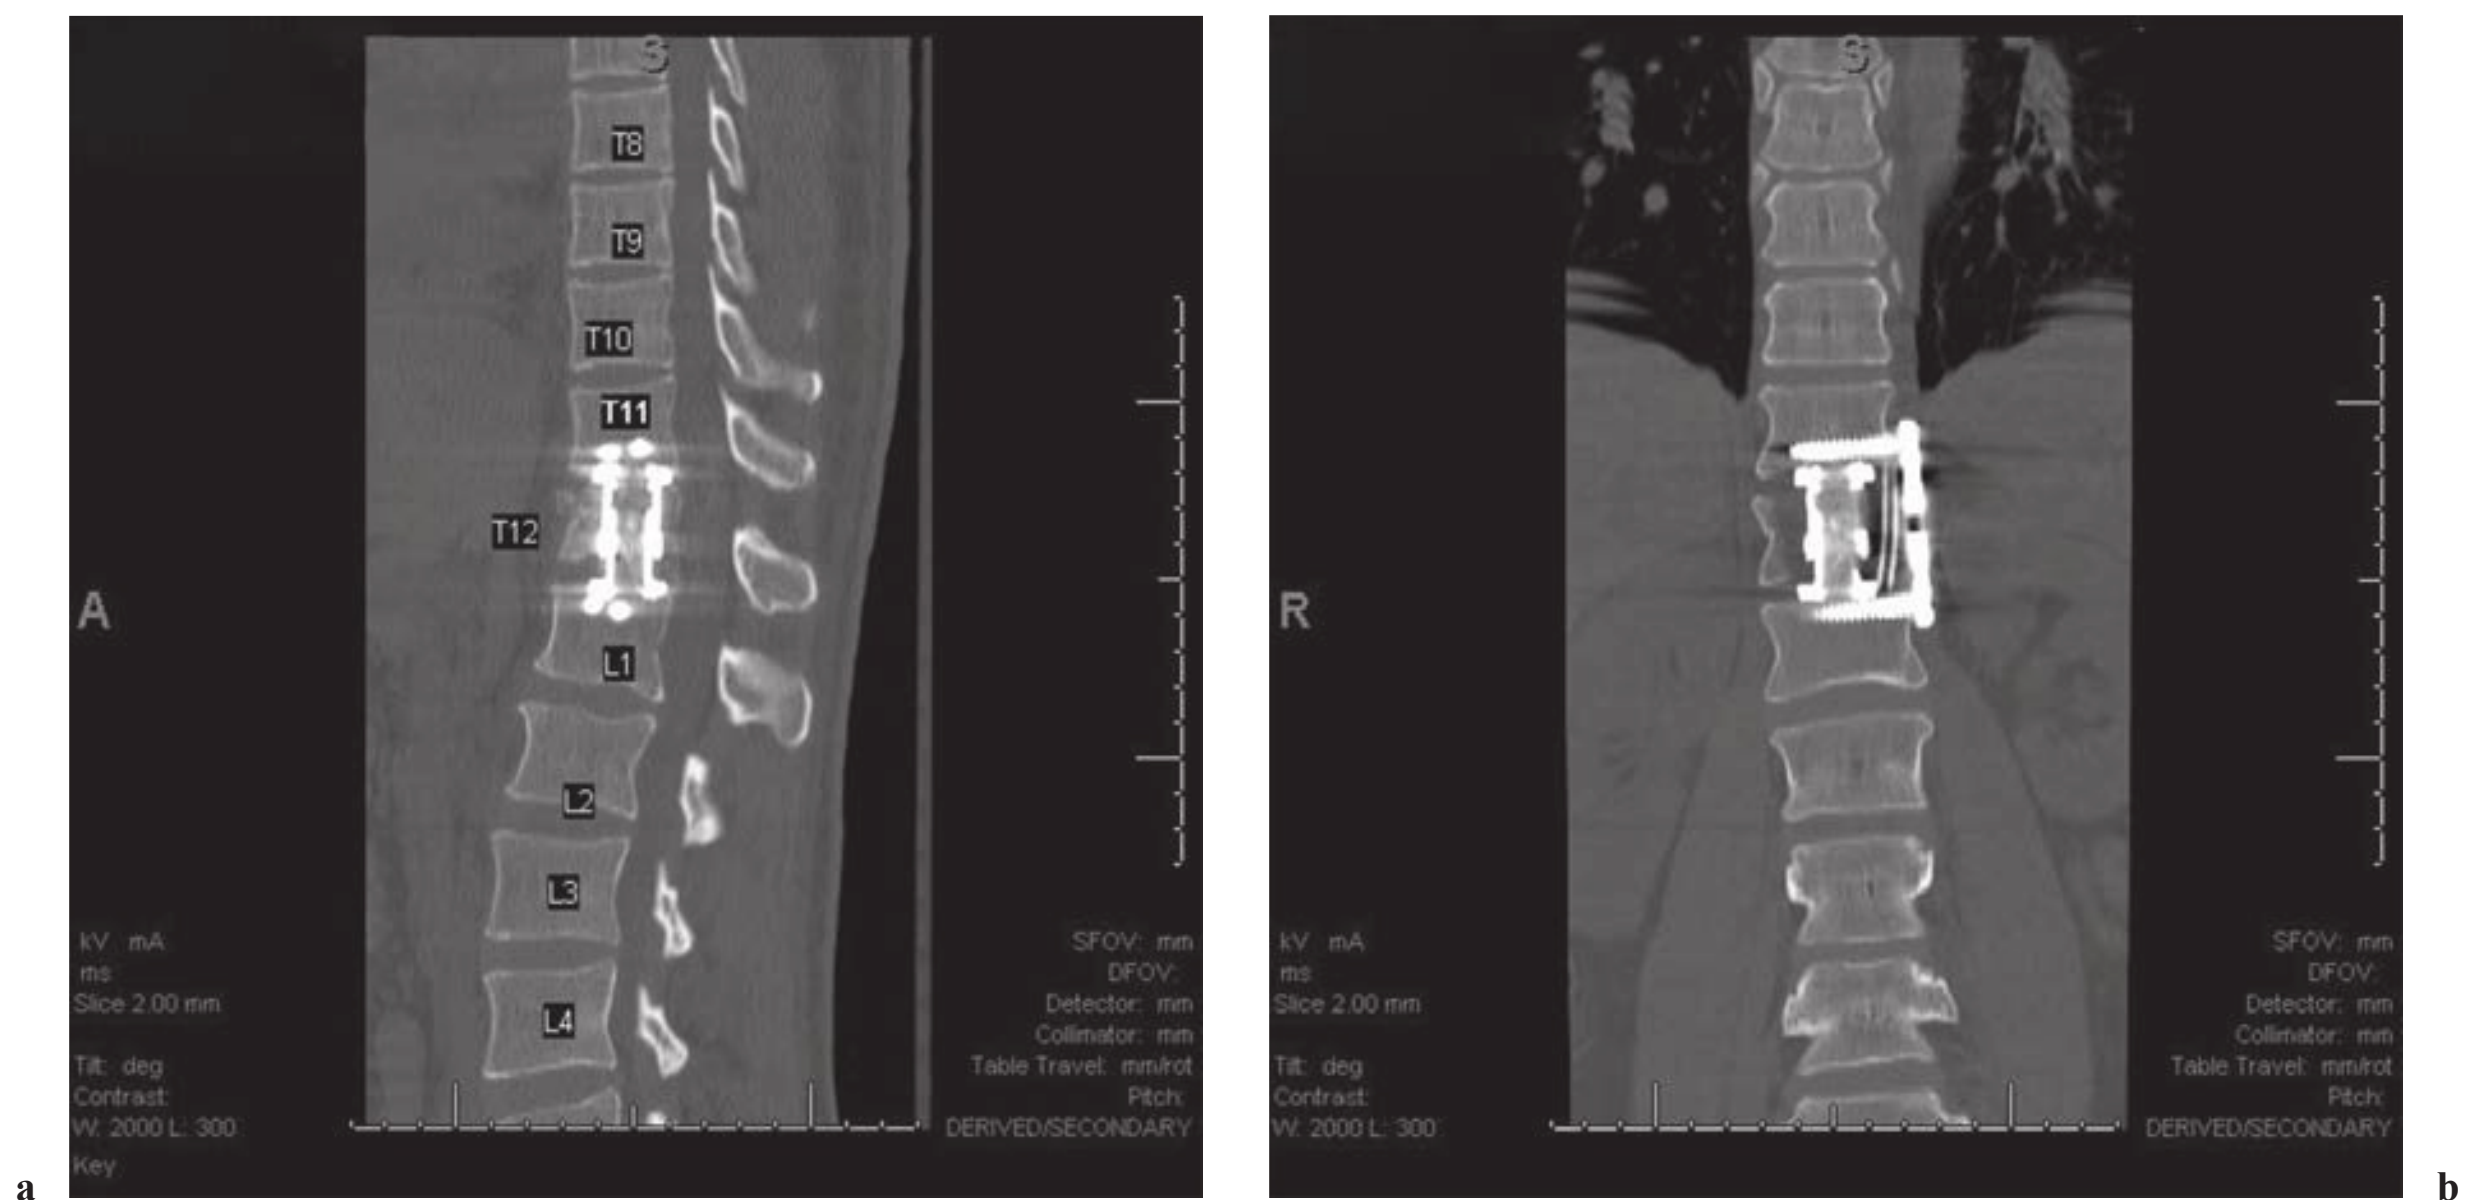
a, b Postoperative (a) sagittal and (b) coronal images of the same patient depicted in Fig. 15.17. He underwent a minimally invasive transthoracic transdiaphragmatic exposure from T11 to L1 and T12 corpectomy and decompression on spinal cord. T11 to L1 arthrodesis instrumentation was performed using an expandable titanium cage packed with in situ autograft, rib strut autograft, and thoracolumbar plate with screws.
